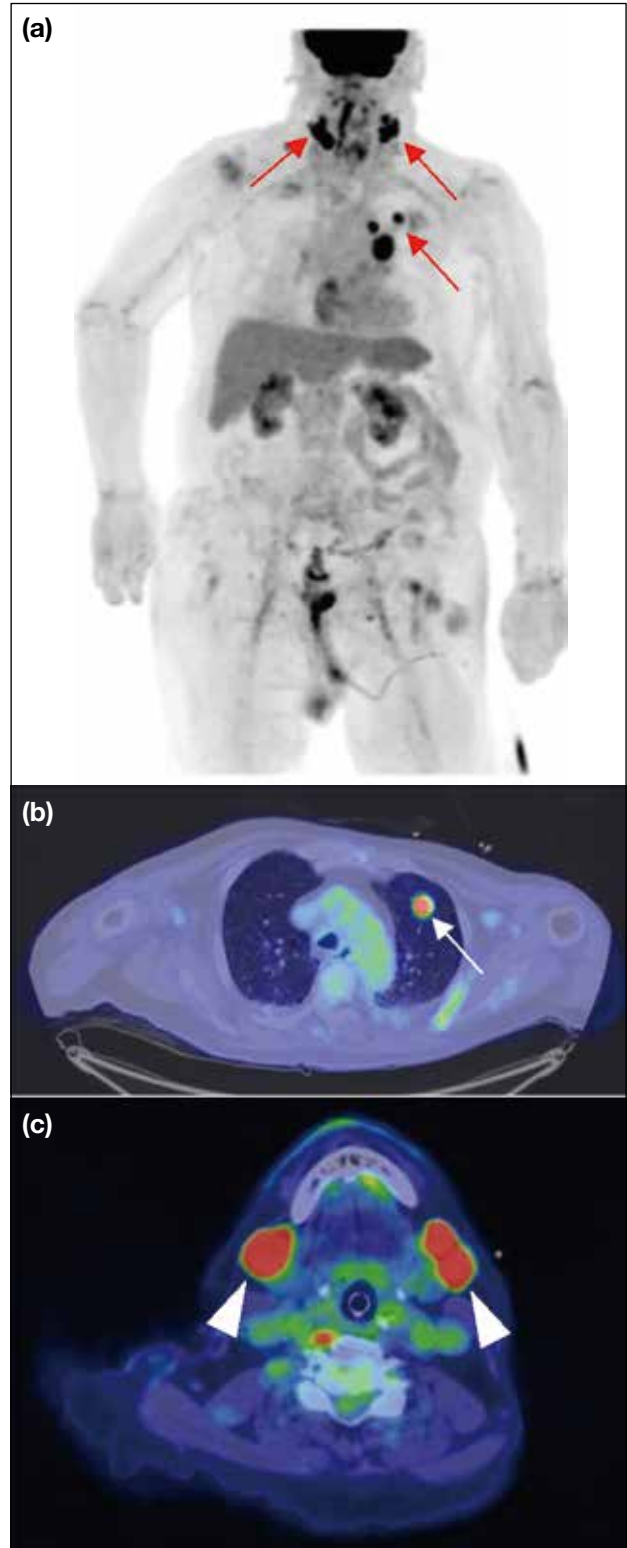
[¹⁸F]fluorodeoxyglucose positron emission tomography/computed tomography of the body. (a) Maximum intensity projection image demonstrating hypermetabolic left upper lobe lung mass with suspected mediastinal, hilar and bilateral cervical nodal metastases (red arrows). (b) Fusion image of the left upper lobe lung mass (white arrow). (c) Fusion image of suspected bilateral submandibular nodal metastases (arrowheads) later biopsy proven to be small-cell lung carcinoma.
